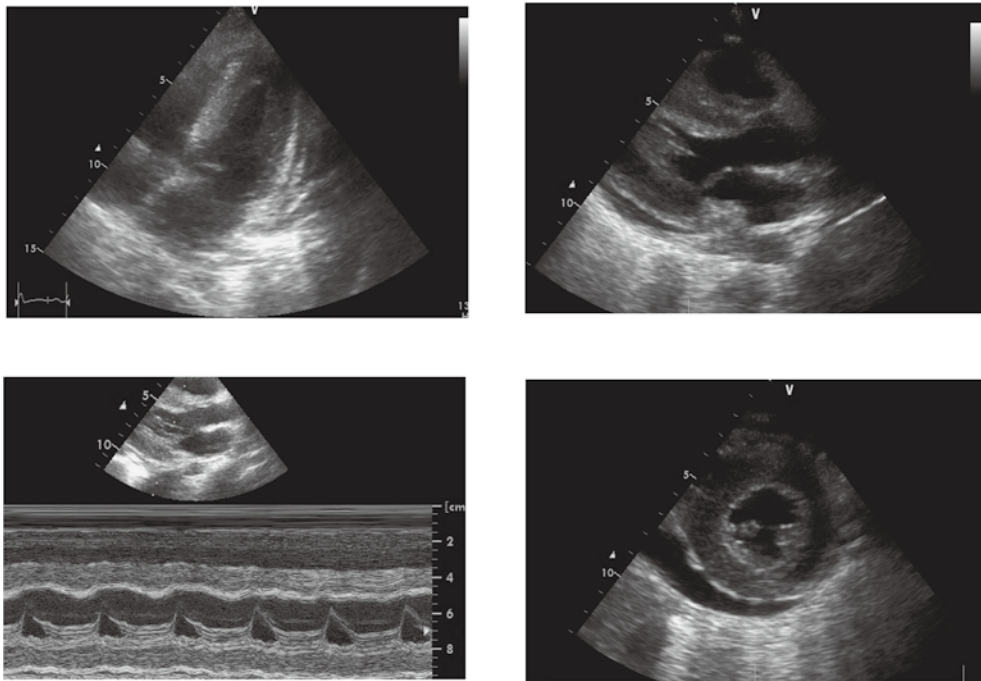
Echocardiography showed pericardial effusion both behind the posterior wall of the left ventricle and ahead of the anterior right ventricle wall in diastole, reduced left ventricular ejection fraction with myocardial thickening on day 5 after BMT.
